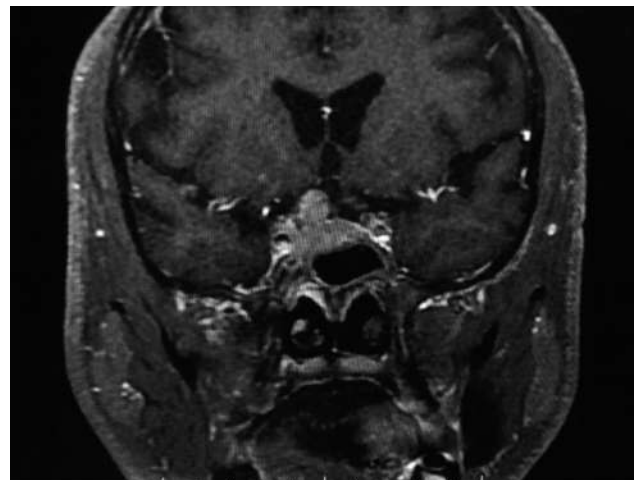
T1-weighted MRI with contrast of the lesion in the sellar region with parasellar and suprasellar extension.
